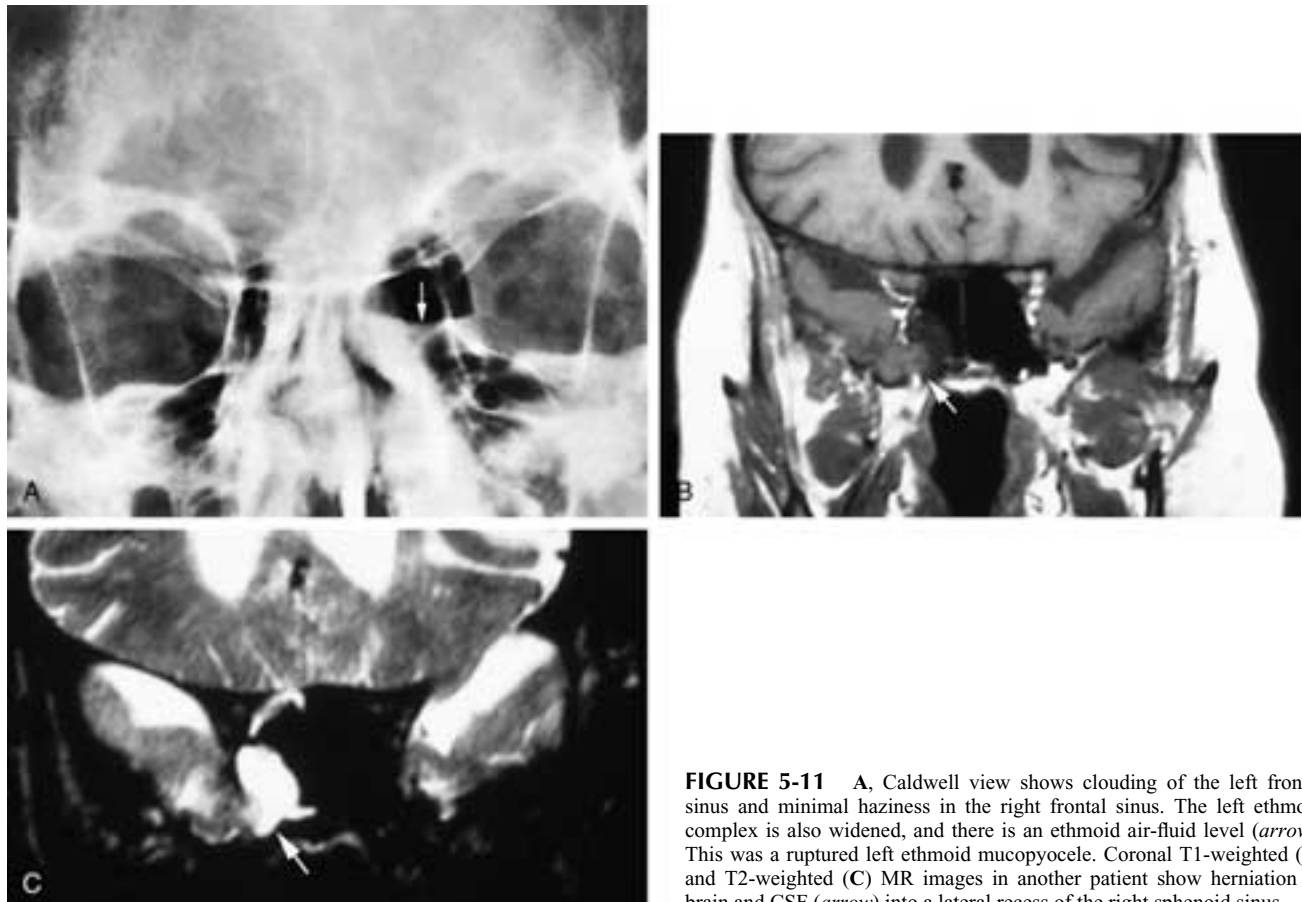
A, Caldwell view shows clouding of the left frontal sinus and minimal haziness in the right frontal sinus. The left ethmoid complex is also widened, and there is an ethmoid air-fluid level (*arrow*). This was a ruptured left ethmoid mucopyocele. Coronal T1-weighted (B) and T2-weighted (C) MR images in another patient show herniation of brain and CSF (*arrow*) into a lateral recess of the right sphenoid sinus.
